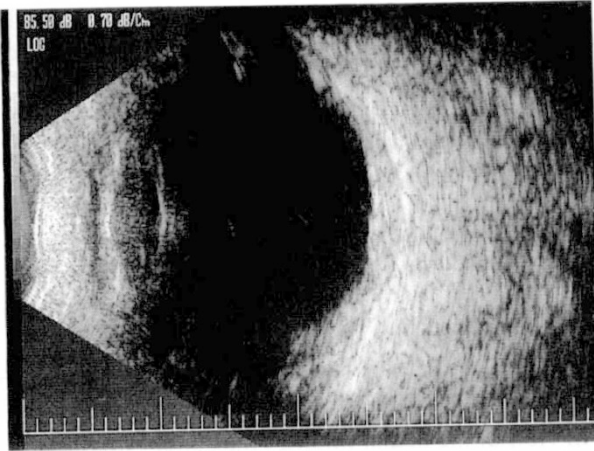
B-scan ultrasound of the right eye shows thickening of the choroid at the posterior pole.
